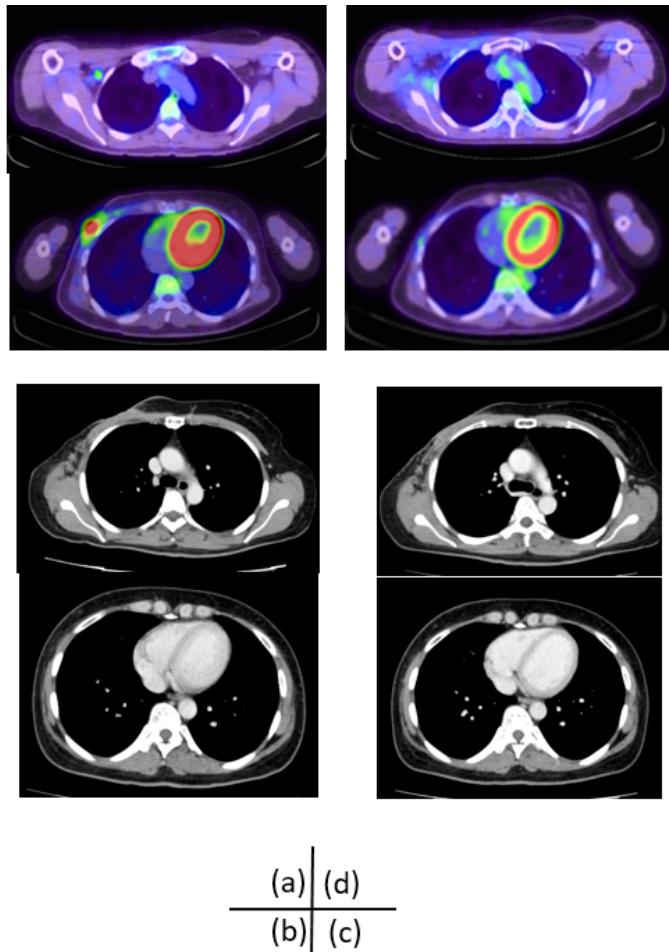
Change in lymph node size during treatment. 18F-fluorodeoxyglucose (FDG) accumulation is observed in the skin and axillary lymph node postoperatively (a). Computed tomography reveals that the size of lymph node has decreased after multidisciplinary treatment (b, c). FDG is no longer present 15 months after surgery (d).
